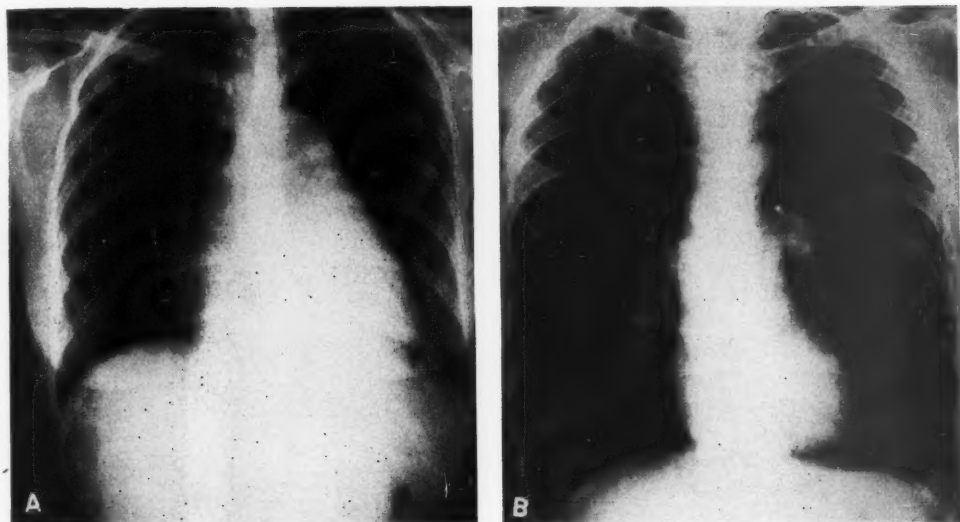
X-ray configuration in cor pulmonale. A. Pulmonary hypertensive heart disease. K.C., age 22, an operating room nurse with essential pulmonary hypertension (see table 1) on the basis of pulmonary arteriosclerosis (autopsy). Note diffuse cardiac enlargement, enlarged pulmonary conus, accentuated hilar markings, and decrease in vascularity of the distal segments of the lung fields. B. Emphysema heart. L.O'D., age 58, male salesman, with asthma and emphysema of 20 years' duration (autopsy). Note marked increase in thoracic cage, hyperaeration of lungs, small heart with lifted apex (a sign of right ventricular hypertrophy). Prominence of the pulmonary artery main stem and of the larger branches is present.
